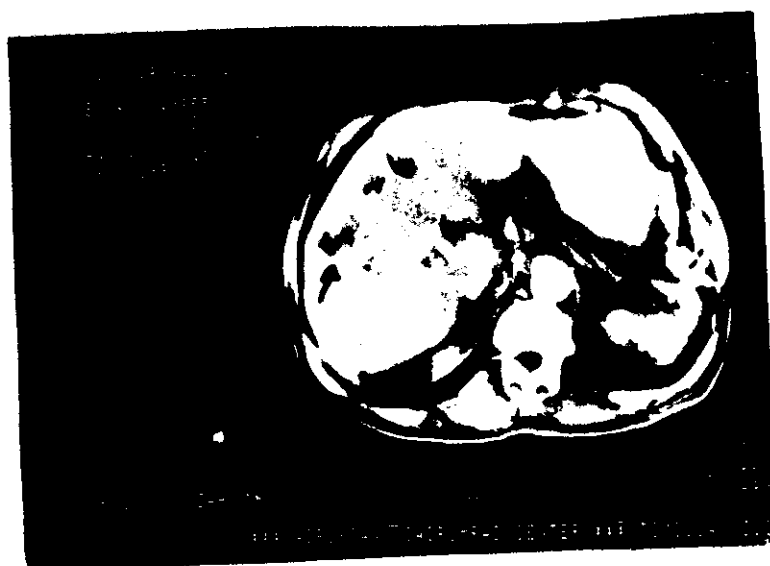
CT scan of liver showing multiple hypodense areas the right lobe denoting neoplasm in the liver.
